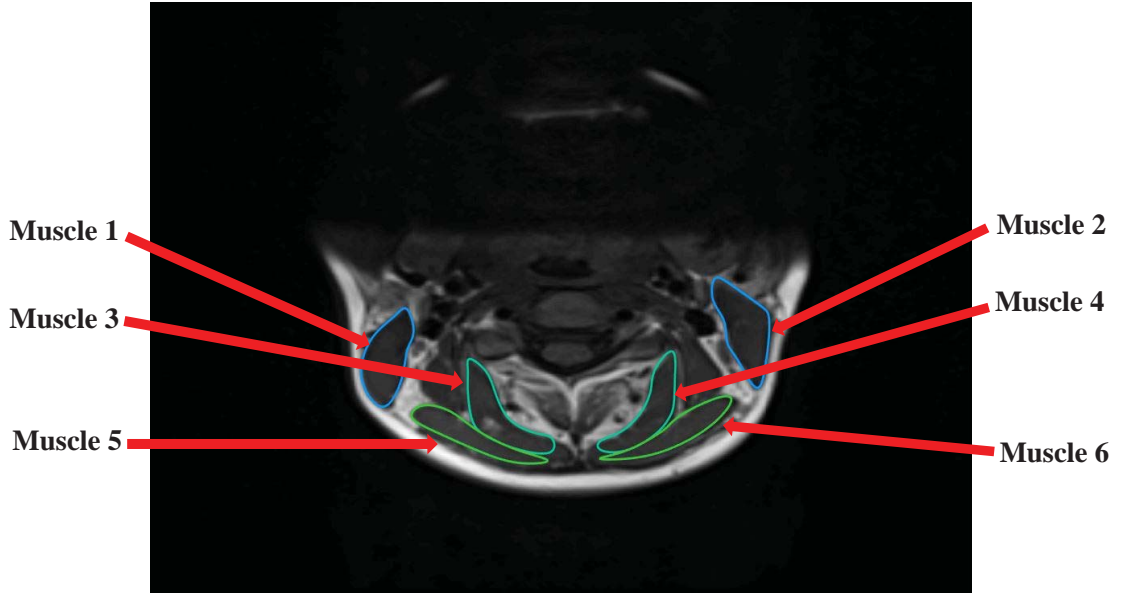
Annotated contours of an axial magnetic resonance image. Different colors are used for each separate muscle due to annotation convenience; however, the same color is used for symmetric muscles.
